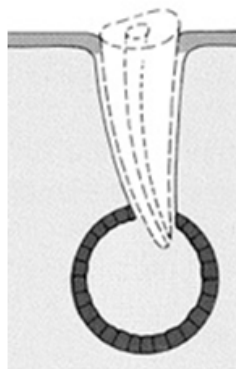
Pathogenesis of a residual periapical cyst [61].
